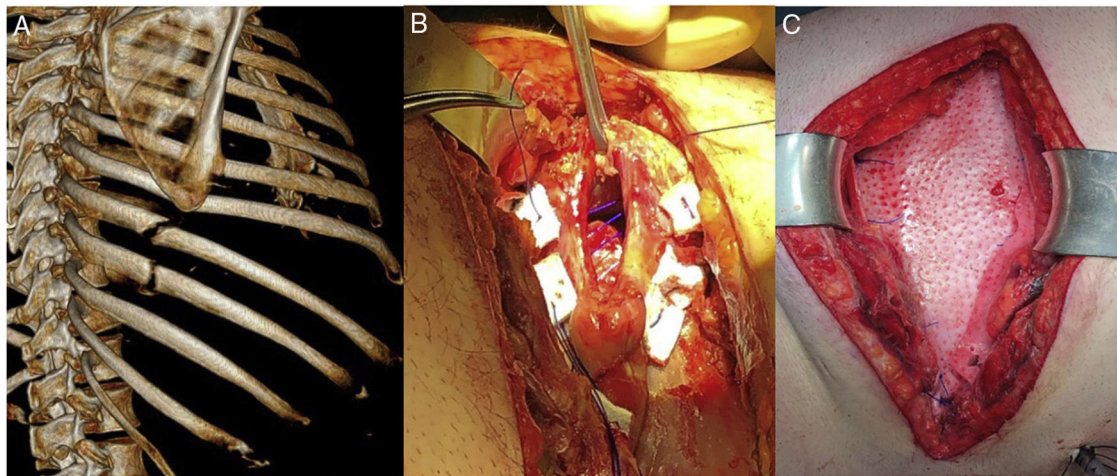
(A) Three-D reconstruction of computed tomography showing fractures of the 7th, 8th and 9th costal arches and intercostal diastasis of the 7th space, associated with pulmonary herniation. (B) Five cm diaphragmatic defect repaired with Prolene[®] and polytetrafluoroethylene sutures. (C) Biological mesh (Permacol[®]) on costal plane.
